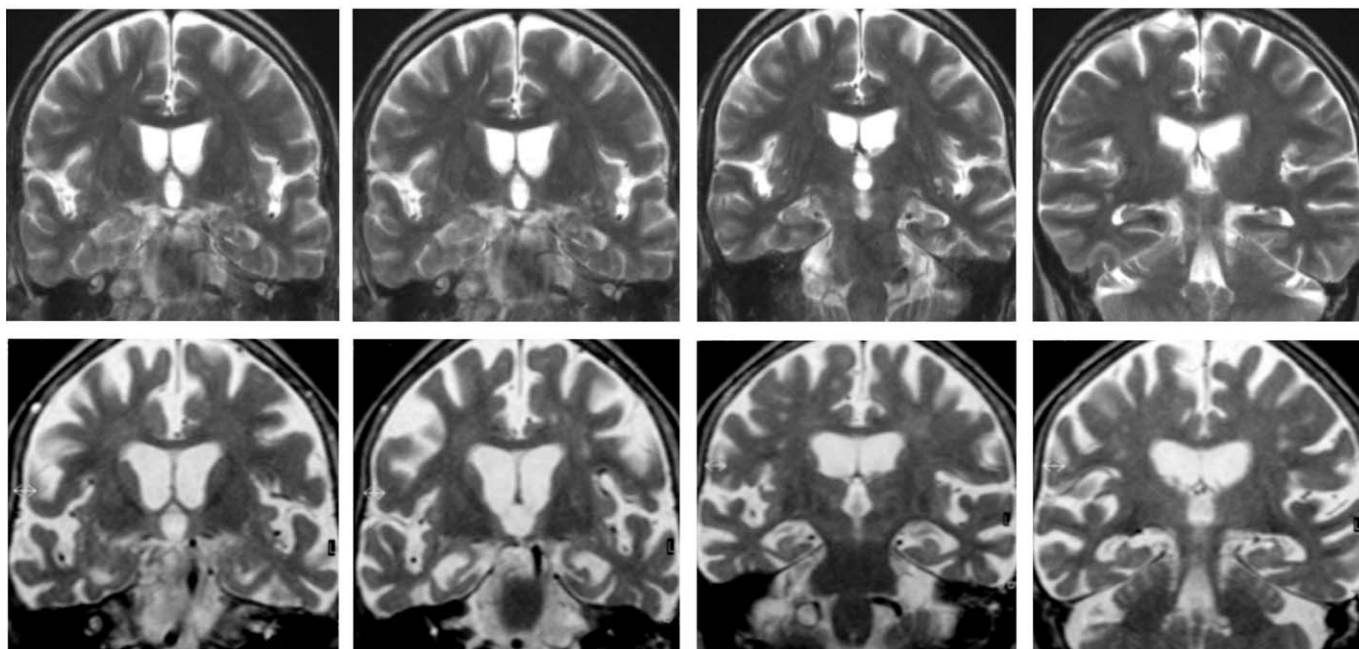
Structural magnetic resonance imaging (MRI). Coronal T2-weighted sections of a patient with severe Alzheimer's disease (AD; lower row) and of a healthy age-matched 75 years old control (upper row). Severe atrophy of the hippocampus, parahippocampal and fusiform gyri, and diffuse atrophy of the temporal neocortex are clearly noticeable. The temporal horns of the lateral ventricles are grossly enlarged. Courtesy of Dr A Erbetta.
